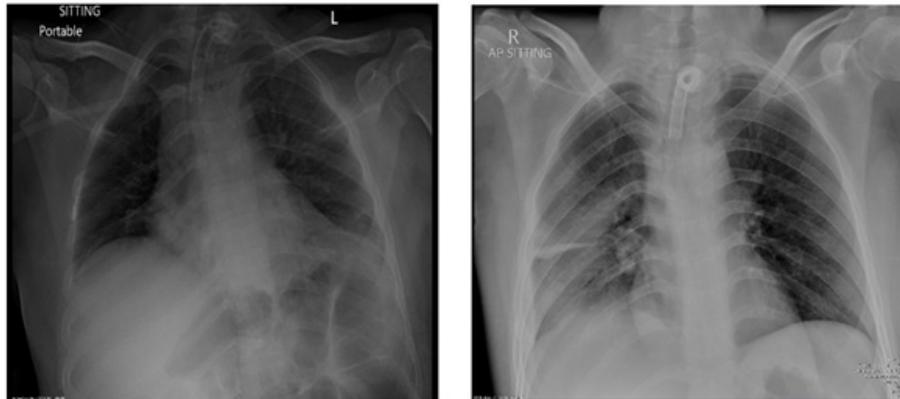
Chest X-ray showed Increased Opacity in the Right Lower Lobe with Subsegmental Atelectasis
